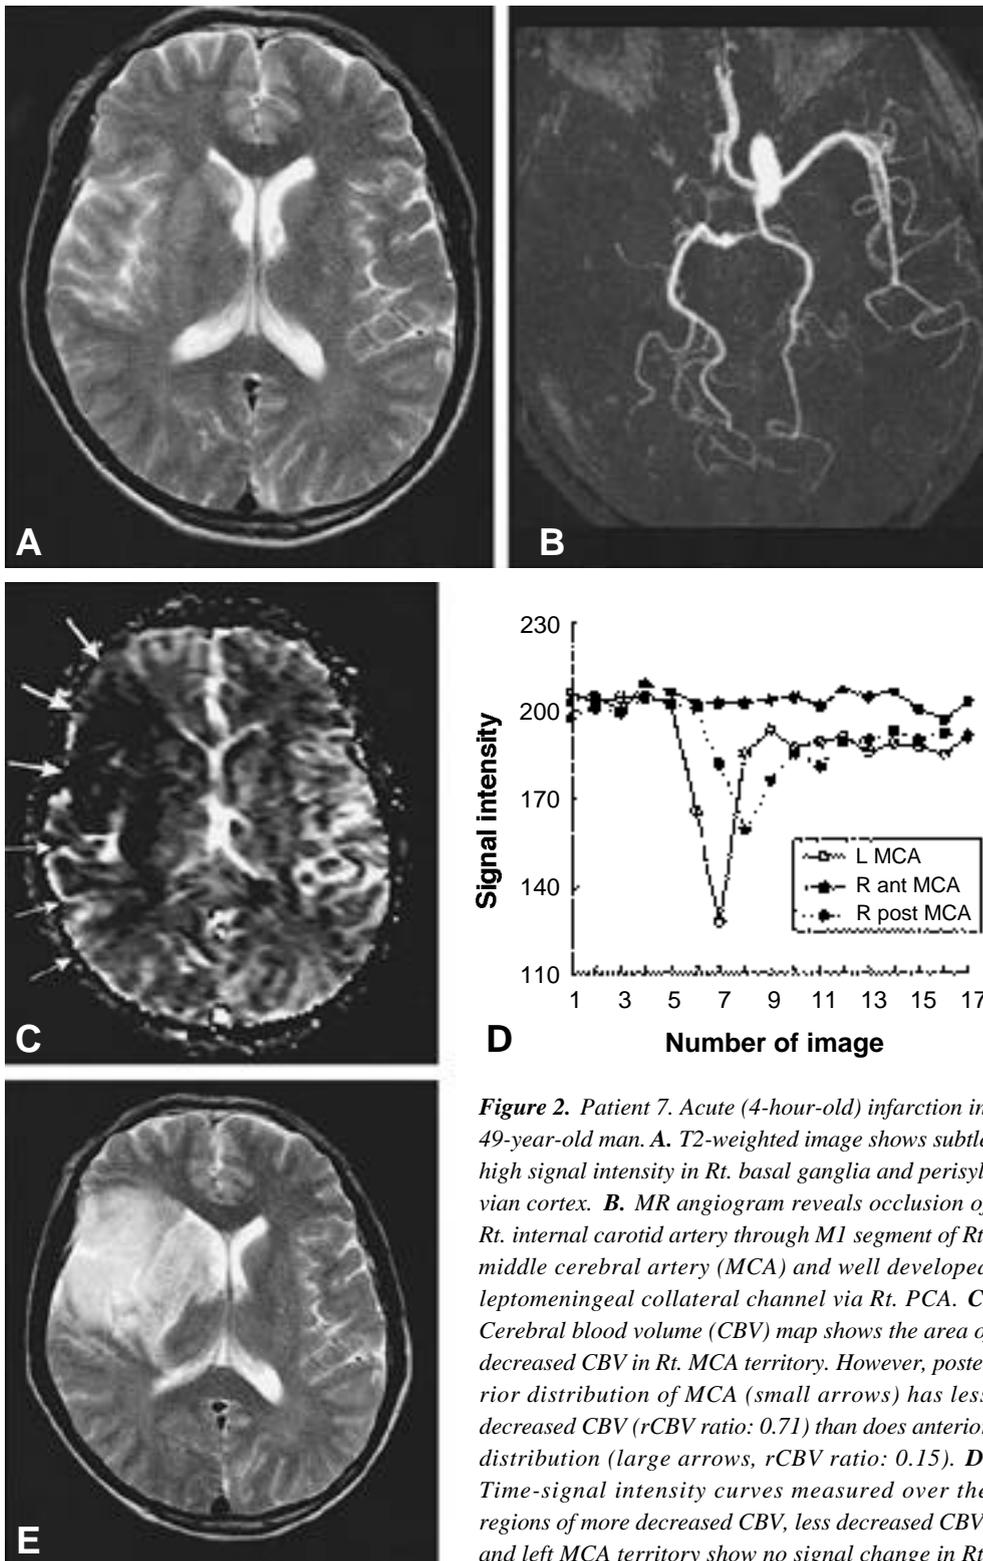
Patient 7. Acute (4-hour-old) infarction in 49-year-old man. A. T2-weighted image shows subtle high signal intensity in Rt. basal ganglia and perisylvian cortex. B. MR angiogram reveals occlusion of Rt. internal carotid artery through M1 segment of Rt. middle cerebral artery (MCA) and well developed leptomeningeal collateral channel via Rt. PCA. C. Cerebral blood volume (CBV) map shows the area of decreased CBV in Rt. MCA territory. However, posterior distribution of MCA (small arrows) has less decreased CBV (rCBV ratio: 0.71) than does anterior distribution (large arrows, rCBV ratio: 0.15). D. Time-signal intensity curves measured over the regions of more decreased CBV, less decreased CBV, and left MCA territory show no signal change in Rt.
